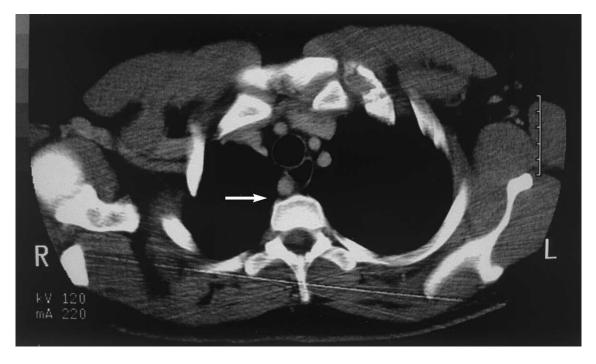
CT scan demonstrates aberrant right subclavian artery (arrow).
